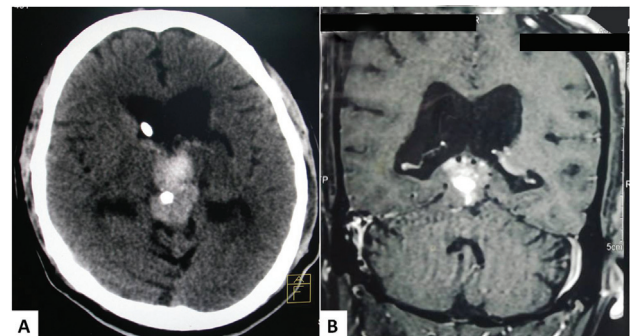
(A) CT image showing a hyperdense space-occupying lesion in the pineal region with internal calcification. (B) MRI image revealing contrast-enhancing nodular mass with scant peritumoral edema.
